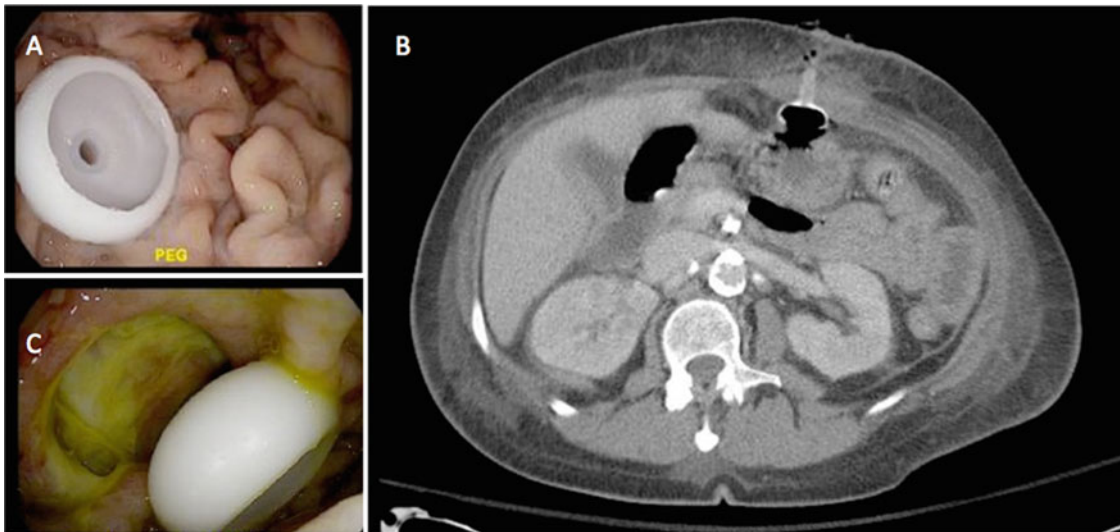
Complications of PEG placement—buried bumper syndrome. A 69-year-old lady with hypertension, diabetes, and left subclavian artery stenosis s/p stenting presented to the hospital with left sided weakness and falls. MRI of her brain showed a new right anterior cerebellar stroke. She underwent uneventful PEG tube placement (a) but on postoperative day 8, she was noted to have fevers, chills, and foul
